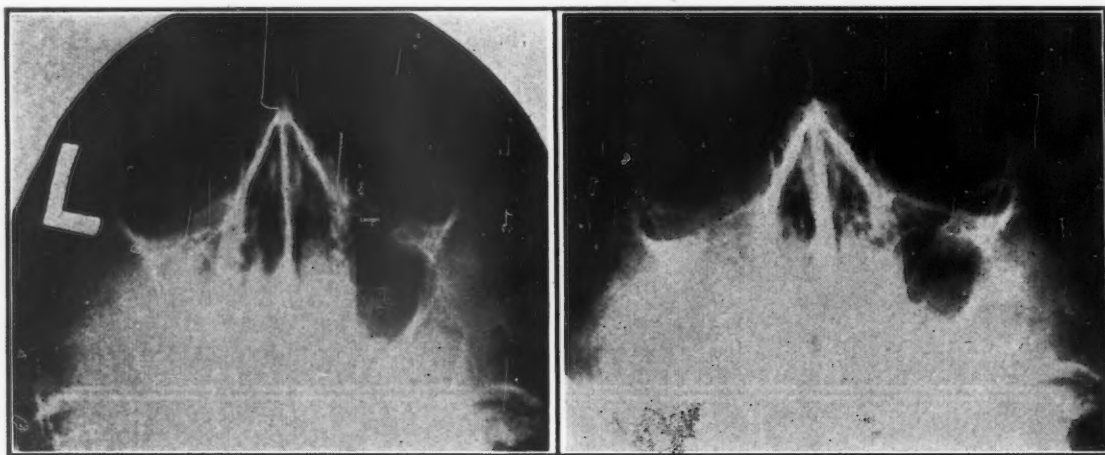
The x-ray films show a fracture of the left zygomatic bone before and after reduction and support by the metal splint.
